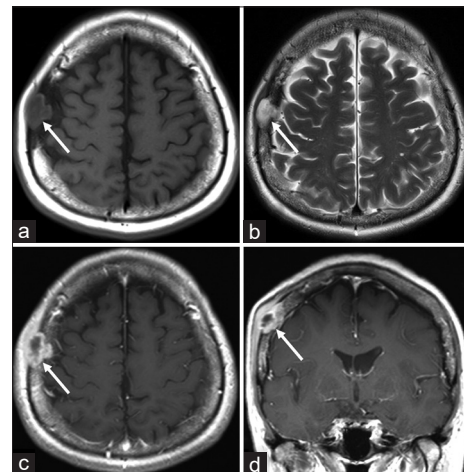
Axial T1- (a) and T2- (b) weighted magnetic resonance imaging showing a calvarial tumor presenting iso/low intensity on T1- and high intensity on T2-weighted images, and well demarcated from the surrounding tissue (arrow). Post contrast axial (c) and coronal (d) T1-weighted magnetic resonance imaging showing heterogeneous enhancement of the tumor with the inner part adjacent to the dura mater (arrow). Note that the temporalis muscle and subcutaneous tissue adjacent to the tumor are extensively swollen and enhanced compared to those on the contralateral side.
